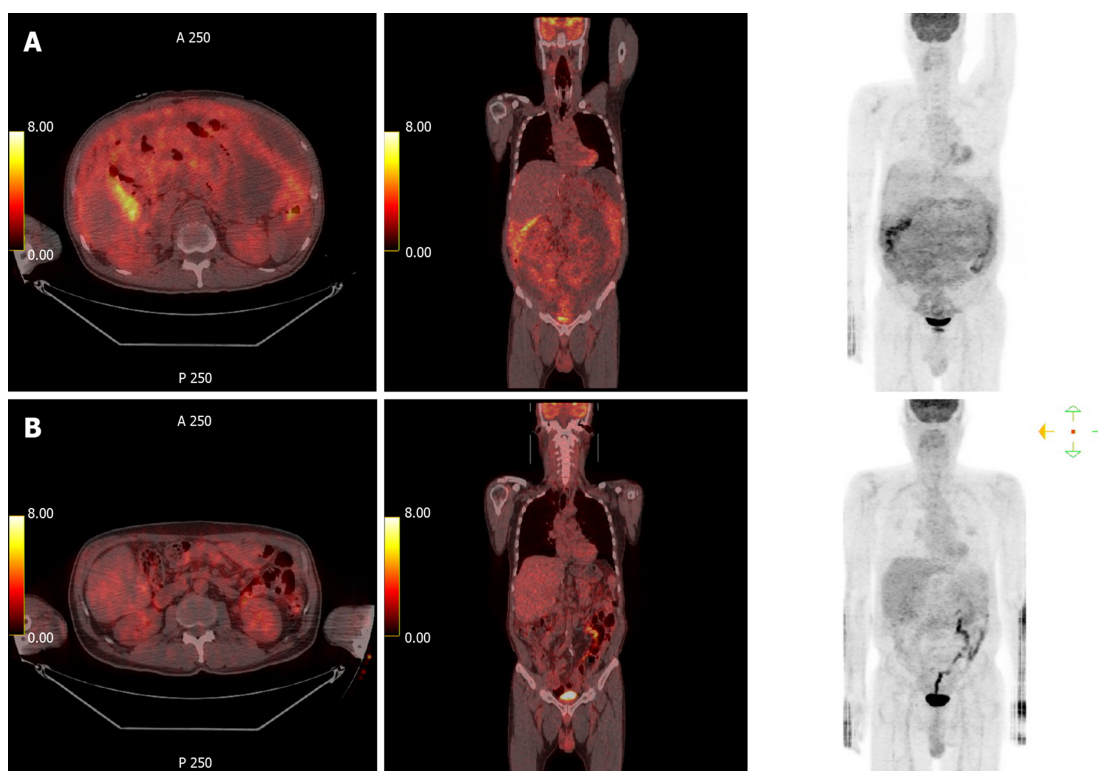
Positron emission tomography-computed tomography. A: Positron emission tomography (PET)-computed tomography (CT) did not depict abnormal hypermetabolism in solid organs, lymph nodes, or digestive organs, but it did depict diffuse hypermetabolism in the peritoneum and omentum; B: Post-chemotherapy PET-CT depicted loss of diffuse hypermetabolic lesion in the peritoneum.
